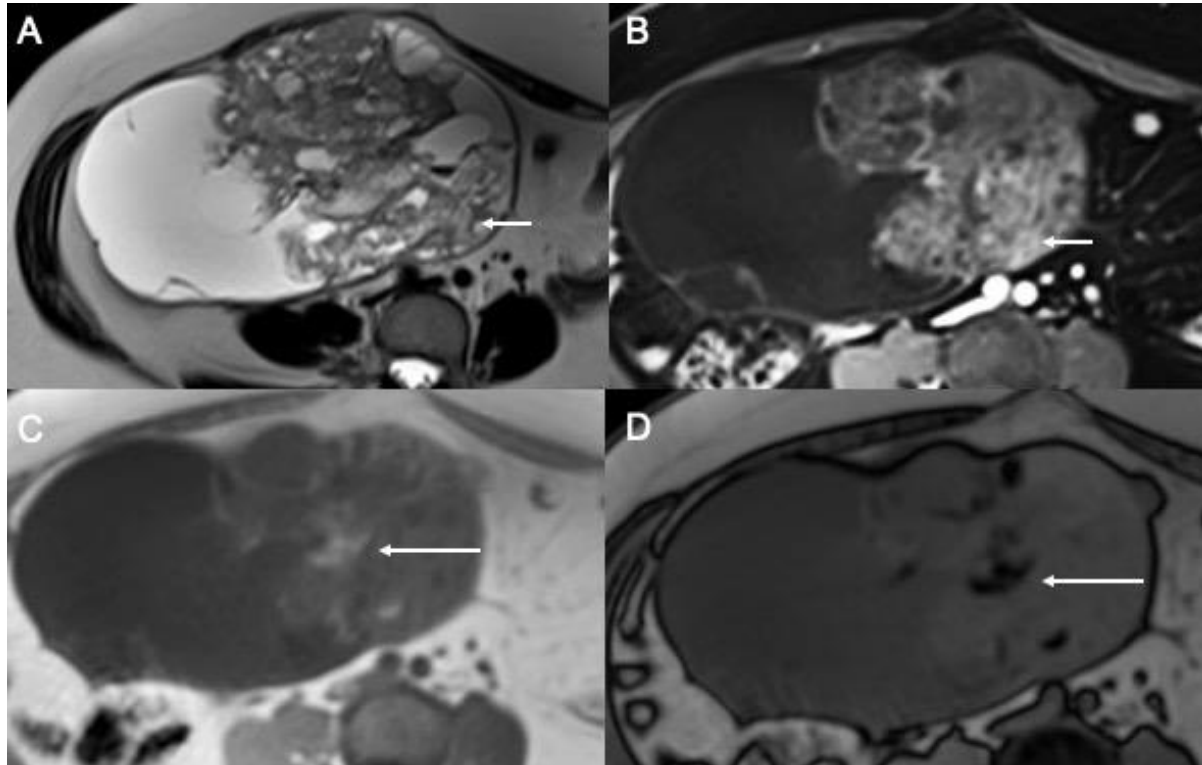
MRI of an immature teratoma: there is a solid and cystic mass in the right ovary, which has small areas of fat component (white arrows) demonstrated by loss-of-signal on the opposed phase (C and D). After contrast administration, the solid areas show intense enhancement (B, short arrows).
